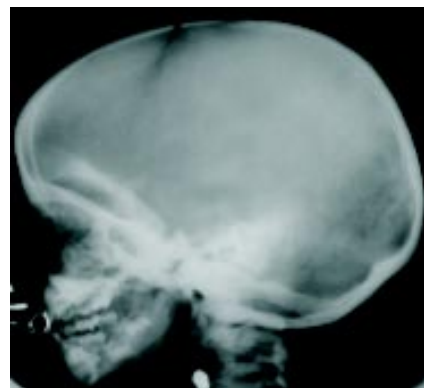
Skull radiograph showing absence of mastoid air cells and densely sclerotic bones of the skull base.
